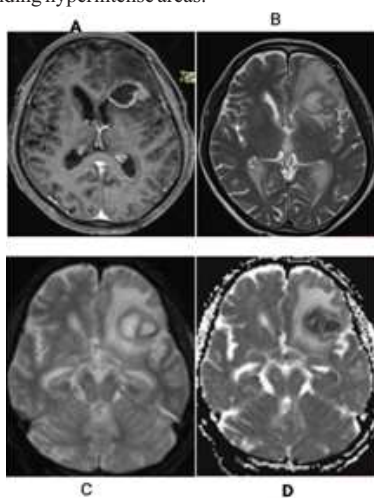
CNS Lymphoma- T1 post contrast (A) in immunocompromised patient showing well defined peripherally enhancing lesions in corpus callosum, right middle frontal gyri, left superior frontal gyrus, left corona radiata. They are appearing T2 (D) hyperintense showing diffusion restriction on DWI(B) with corresponding drop on ADC(C)
